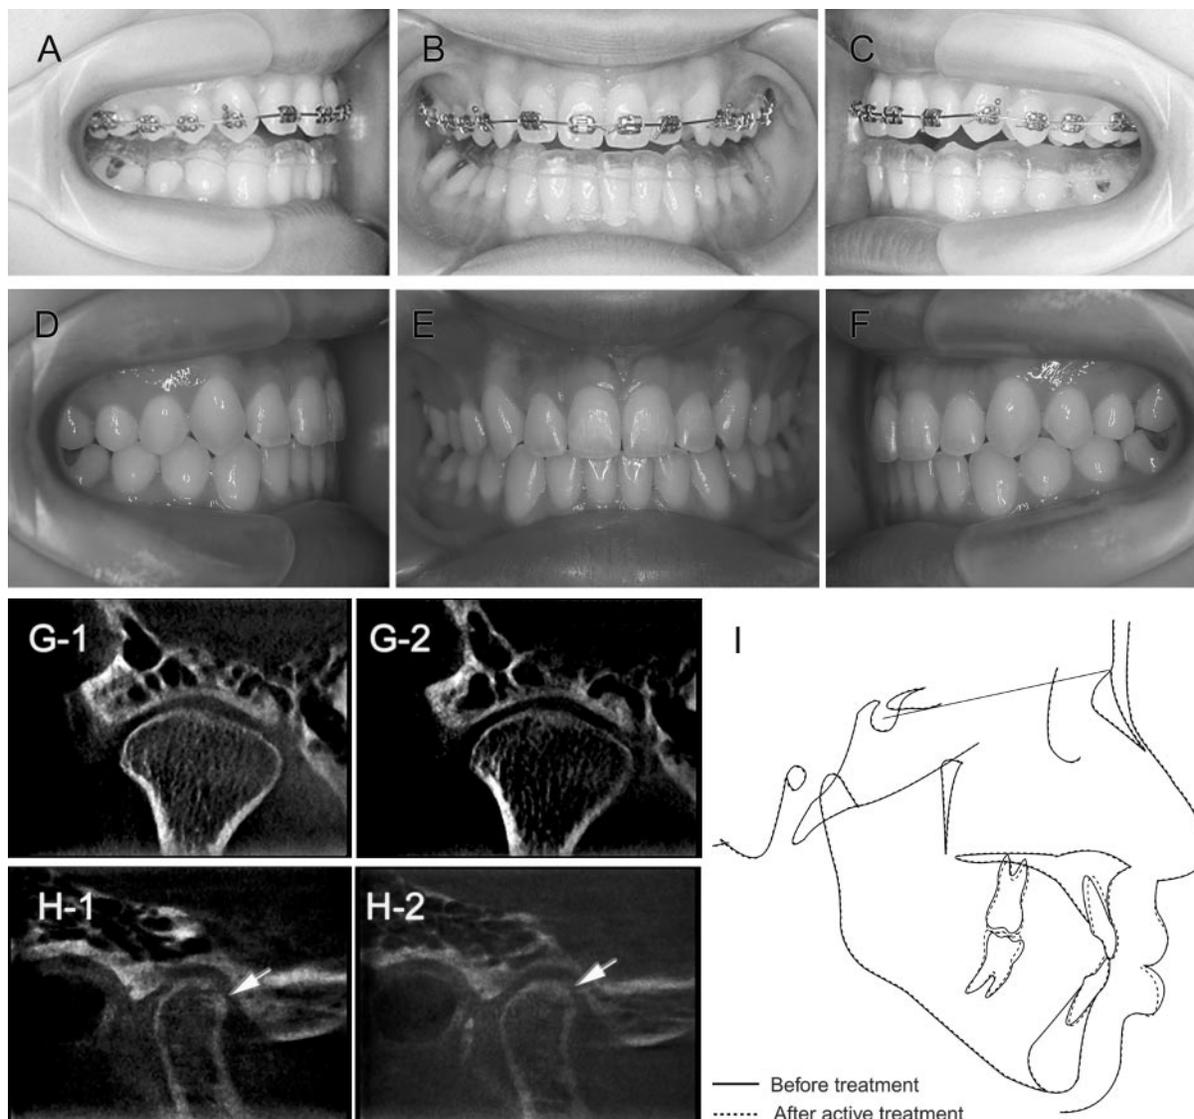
Case 3: (A–C) Oral photograph during orthodontic treatment. The patient was wearing a stabilization-type splint. (D–F) Oral photograph after orthodontic treatment. (G 1,2) Frontal 3DX images of left temporomandibular joint (TMJ) after treatment. (H 1,2) Sagittal images. The single arrow indicates the TMJ cortical bone. (I) Cephalometric superimposition in pre- and posttreatment radiographs.
